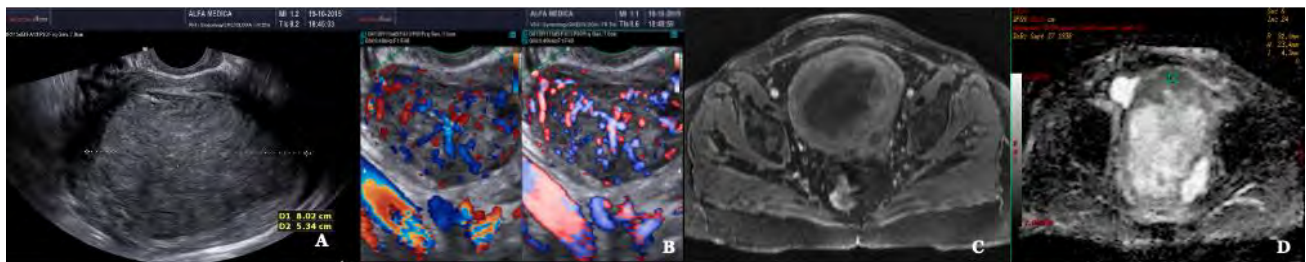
Leiomyosarcoma A Conventional ultrasound scanning B Doppler enhanced ultrasound scanning (left) Power Doppler enhanced ultrasound scanning (right) C MRI T2 image D MRI ADC mapping ADC in the lower range:  $0,9 \times 10^{-3}$
